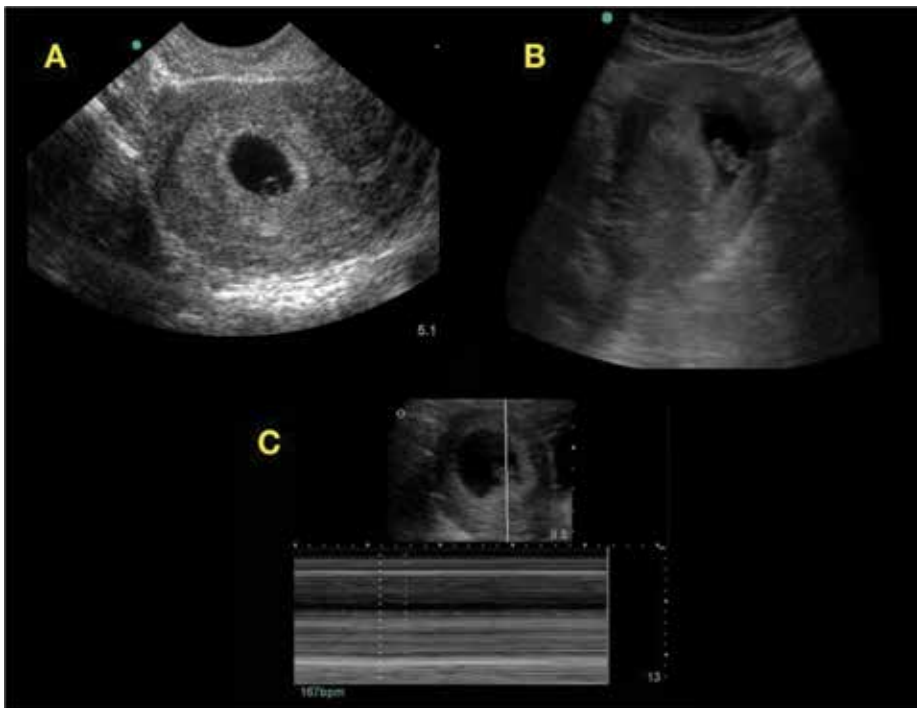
Pelvic ultrasound demonstrating signs of definitive intrauterine pregnancy. (A) Yolk sac within the gestational sac. (B) Fetal pole. (C) M-mode demonstrating the measurement of fetal heart rate.
